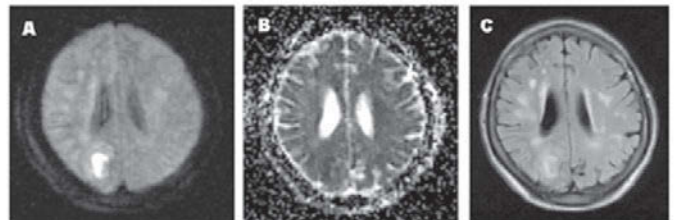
MRI imaging performed on day 8 of illness. DWI shows very high signal intensity (so called "lightbulb sign") in the right occipital lobe (A). The region of increased DWI signal demonstrates low signal on ADC map (B), which is typical for true restricted diffusion, and hyperintensity on the FLAIR image (C). This appearance corresponds to cytotoxic edema being found in several conditions such as acute stroke and herpes encephalitis, however occipital lobe is not typical localization of latter one.
